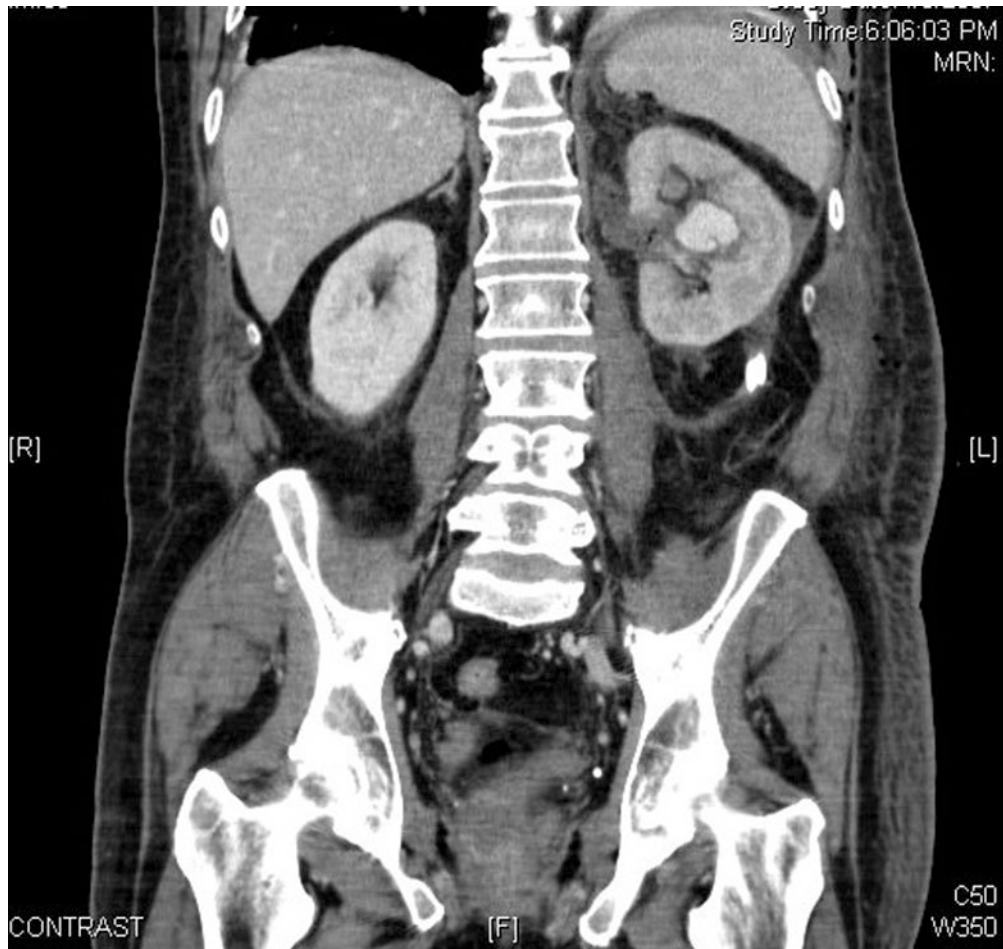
Computed tomography 2 days after laparoscopic partial nephrectomy demonstrating a distinct blush during the arterial phase, characteristic of a segmental renal arterial pseudoaneurysm
